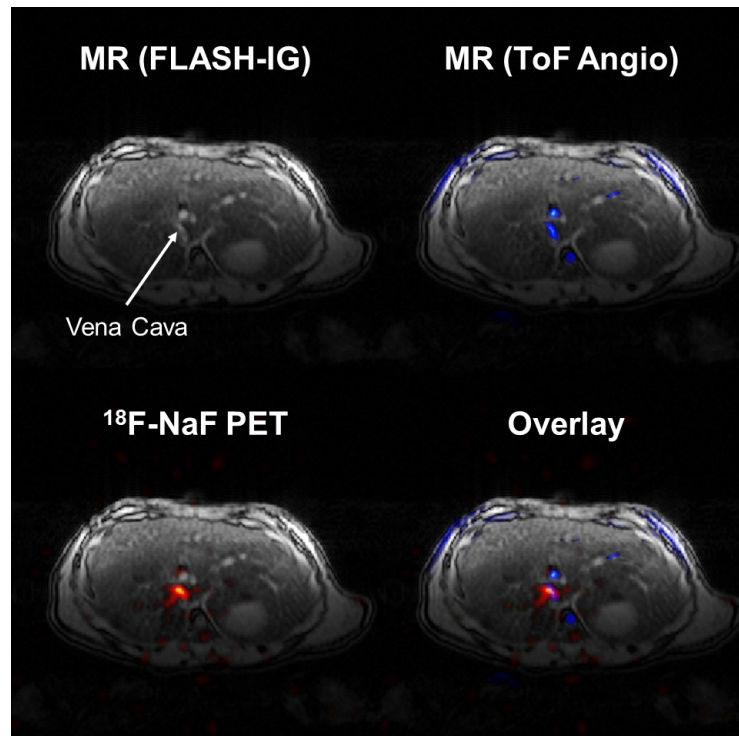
Detection of VC ROI from ^{18}F -NaF images. Clear VC signal on early time frame PET images (approx. 10s post injection, 5s duration) with overlay of FLASH MR images (top left, arrow indicates VC region). ToF angiography (blue overlay) confirms location to have high blood flow as expected for major blood vessel.
